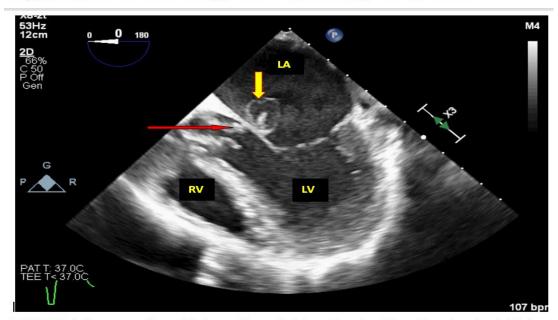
Transoesophageal Echocardiography Four Chamber View Showing Aortic Valve Vegetations (Red Arrow) Touching The Aneurysm(Yellow Arrow) Of Anterior Mitral Leaflet-The Kissing Lesion. LA: left atrium, LV: left ventricle, RV: right ventricle.
